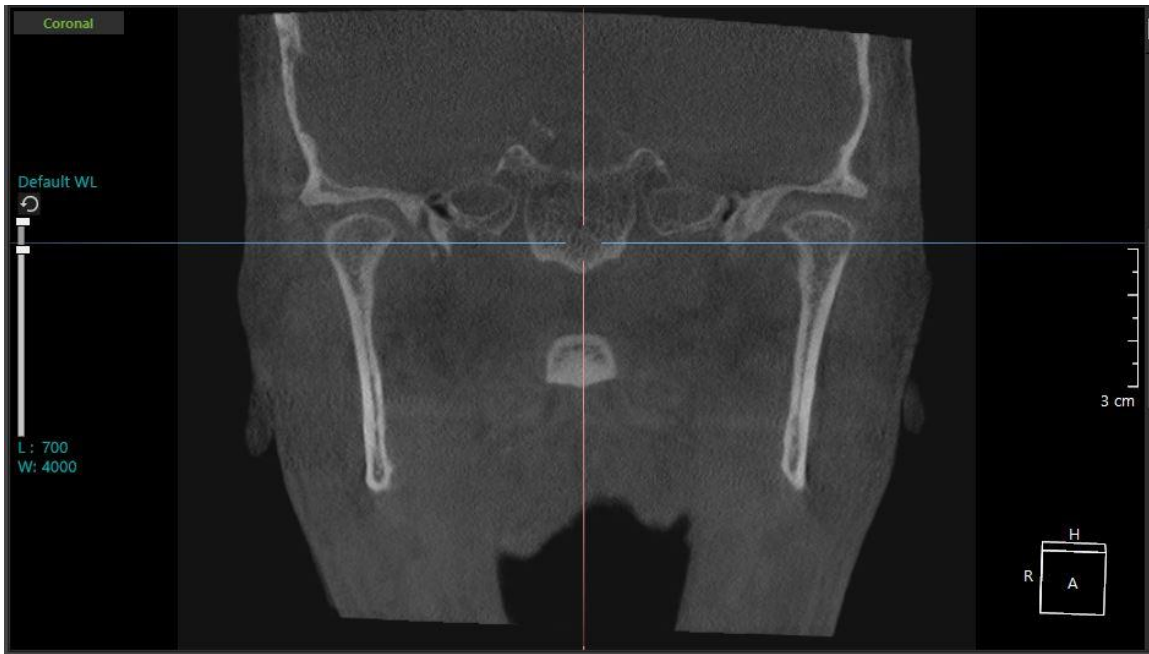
Calibrated CBCT image in the coronal view with the blue line of the calibration tool intersecting both left and right condyles in the middle of the center of rotation.
